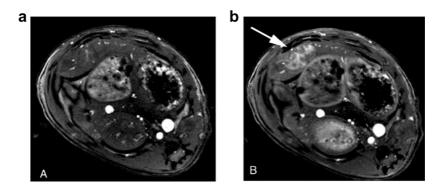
MRI image of the hepatic metastasis (a) before and (b) after the application of the MRI CA.²
